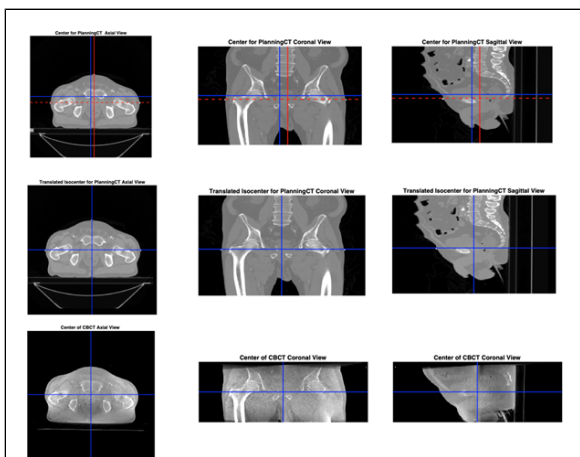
Content of planning CT shifted to the machine isocenter. Top left to right - axial, coronal and sagittal planning CT image with machine isocenter in red and image isocenter in blue. Middle left to right - axial, coronal and sagittal planning CT at machine isocenter. Bottom left to right - axial, coronal and sagittal CBCT at machine isocenter.
